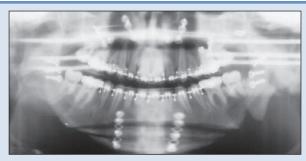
Immediate postoperative panoramic radiograph of the patient in Fig. 4a who underwent a maxillary LeFort I level intrusion osteotomy, a bilateral sagittal split osteotomy to advance the mandible and a stairstep genioplasty.
